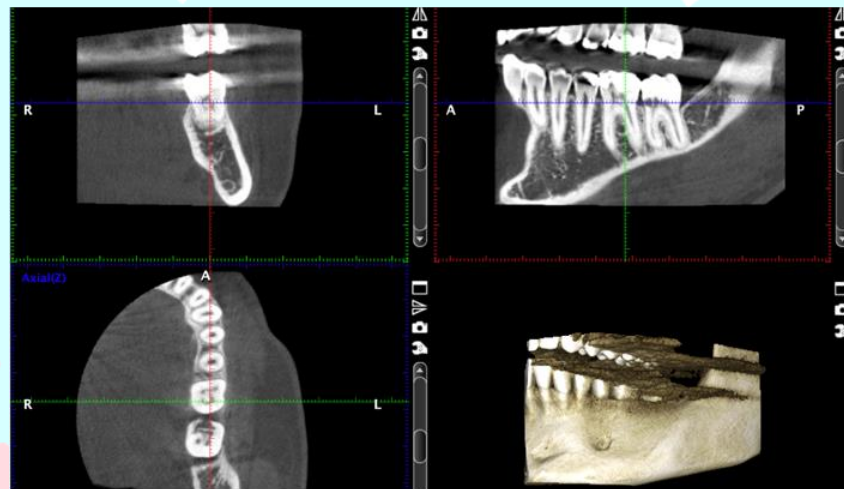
Case presentation - CBCT observation on mesial proximal side of tooth #37 - ECR.
